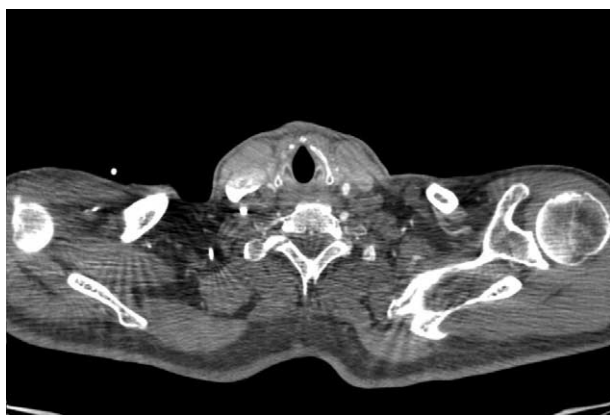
CTA of neck showing dissection of both common carotid arteries with peripheral contrast material showing their patency.
